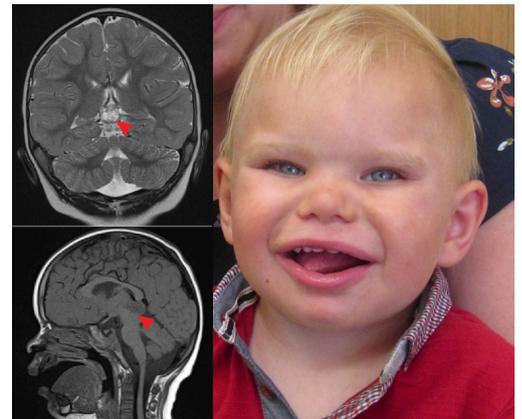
Brain MRI showing complex mass in the pineal region.
